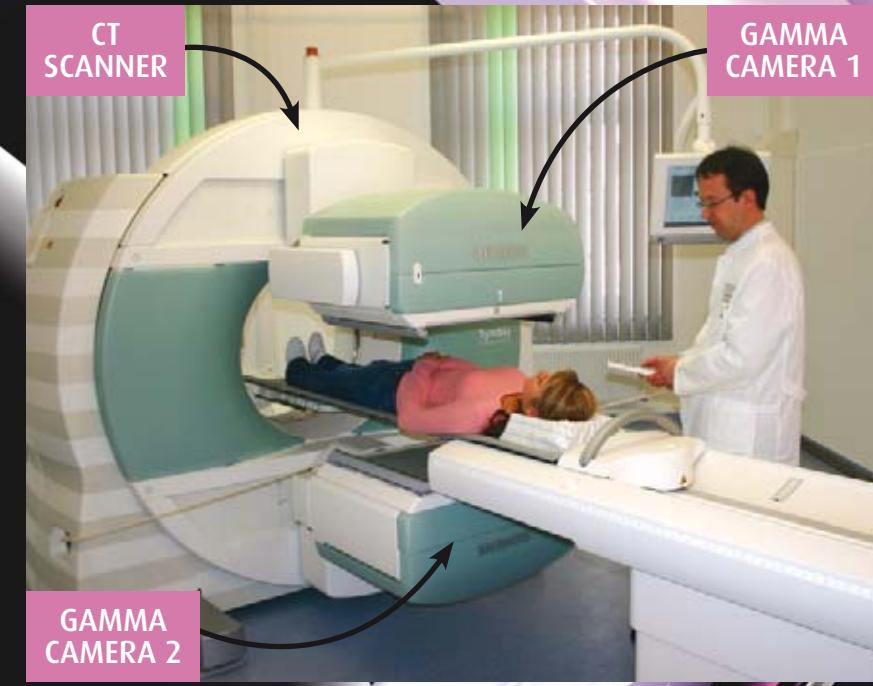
SPECT-CT Unit: CT Studies with SPECT. CT = computed tomography; SPECT = single photon emission CT. Courtesy of Siemens press pictures http://www.siemens.com/press/pool/de/pp_med/2005/sc_upload_file_mednm200504048_03_300dpi_1456207.jpg Accessed January 201113. Annotated by the authors.
